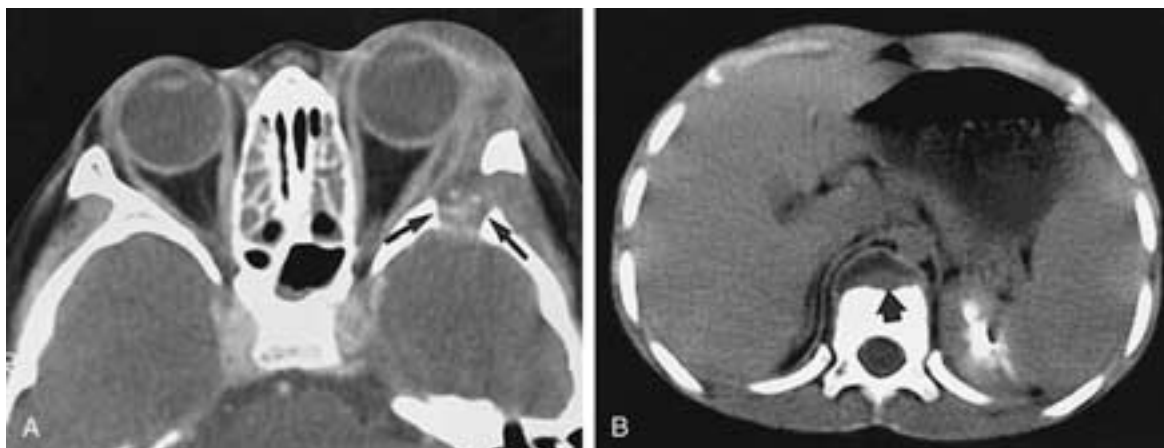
Tuberculosis. A, Enhanced axial CT scan shows a destructive lesion involving the left orbit (*arrows*). B, Axial CT scan through the abdomen shows a prevertebral tuberculous abscess (*arrows*). (From Hidayat AA et al. Langerhans' cell histiocytosis and juvenile granuloma of the orbit. *Radiol Clin North Am* 1998;36:1229–1240.)
